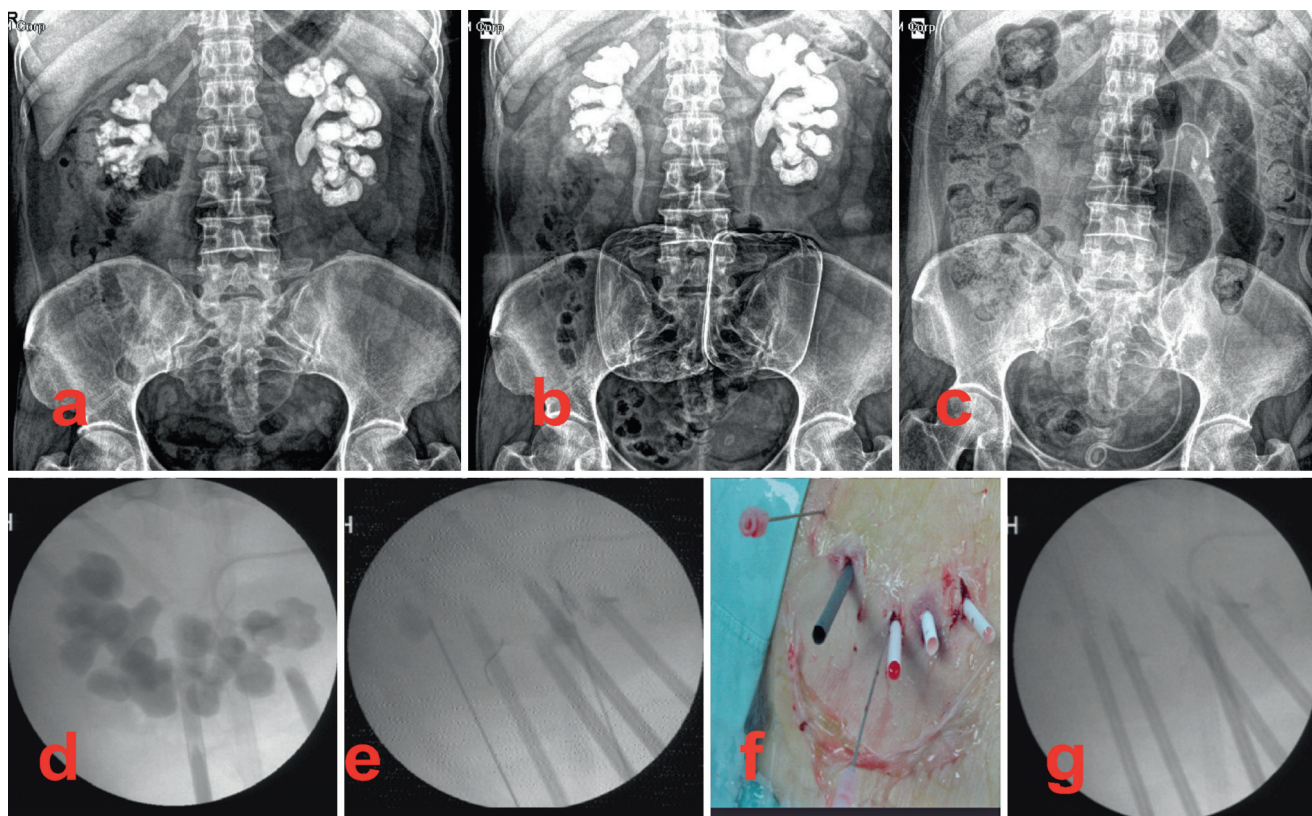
Fluoroscopic view and external view of MPCNL procedures of the same case (a) X-rays of kidneys-ureters-bladder (KUB), (b) intra-venous urogram (IVU), (c) postoperative KUB (d–g)
